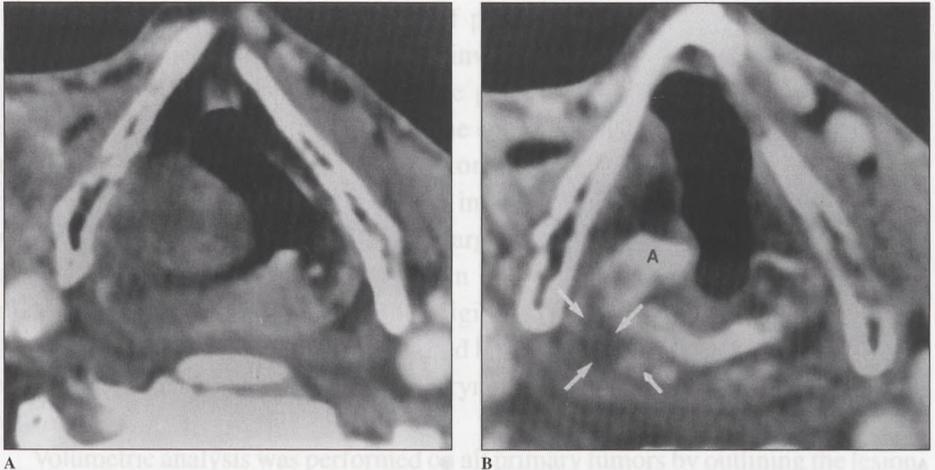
CT images of a 8.9-cm³ pyriform sinus tumor which failed RT. (A) Section through the mid-pyriform sinus shows the tumor bulk involving the entire right pyriform sinus with extension onto the posterior pharyngeal wall as well as the aryepiglottic fold. (B) The true cord level shows bulk (8 x 10 mm) involvement of the pyriform sinus apex, with a discrete mass (small arrow) and obliteration of the deep tissue planes (large arrows). There is associated sclerosis of the ipsilateral arytenoid cartilage (A).
